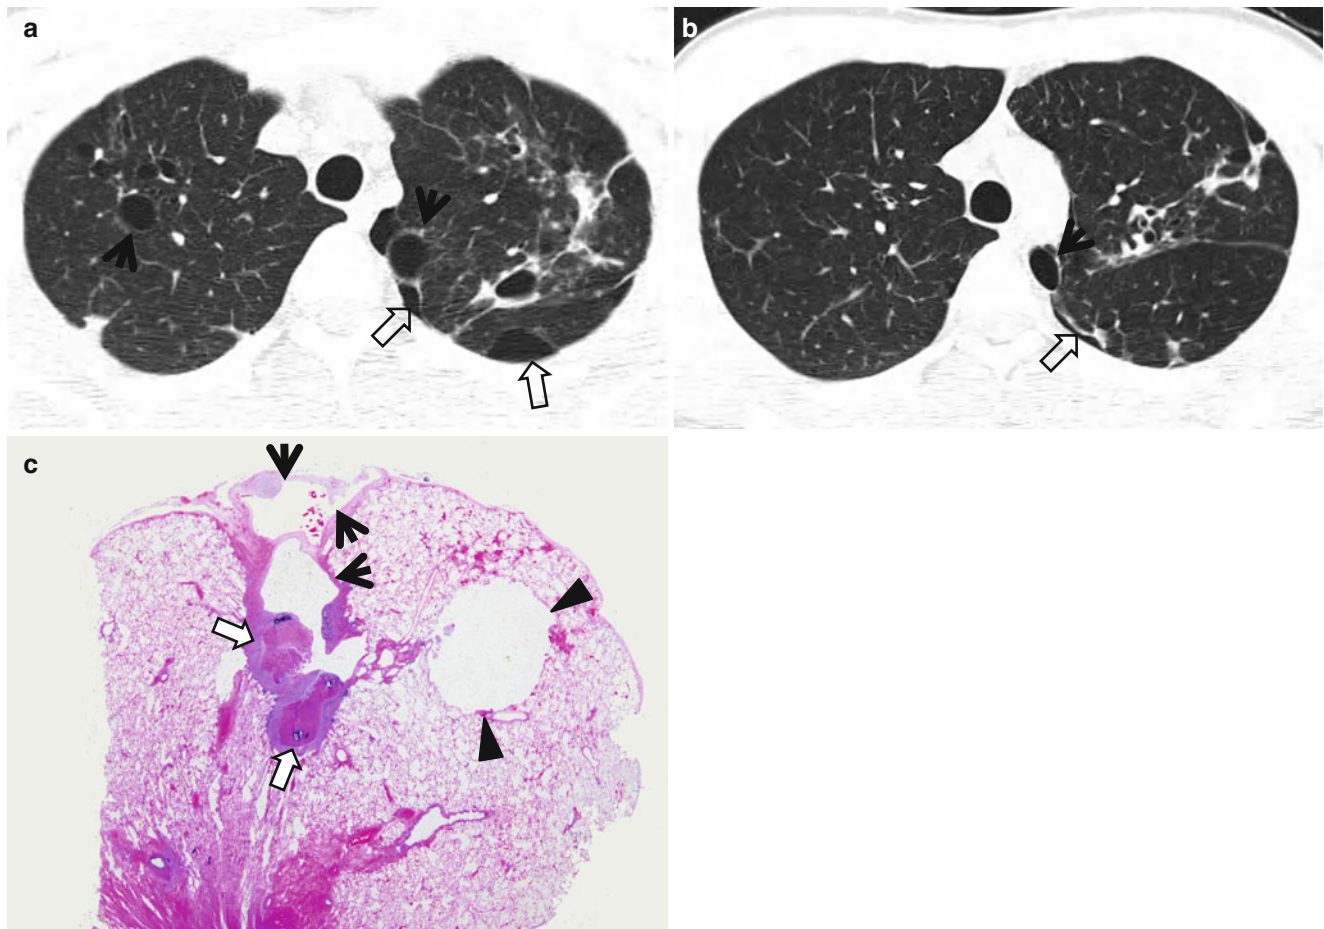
Bullae and tuberculous granulomas in a 56-year-old man. (a, b) Lung window images of CT scans (2.5-mm-section thickness) obtained at levels of great vessels (a) and aortic arch (b), respectively, show multiple small air-filled cysts (bullae) (arrows), variable-sized nodular lesions of tuberculosis, and pneumothorax (open arrows) in left
